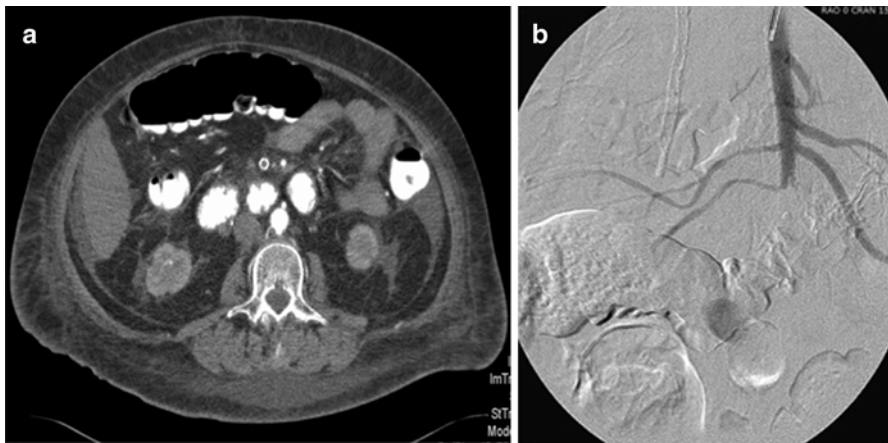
(a) CT scan and (b) diagnostic angiogram of acute SMA occlusion
